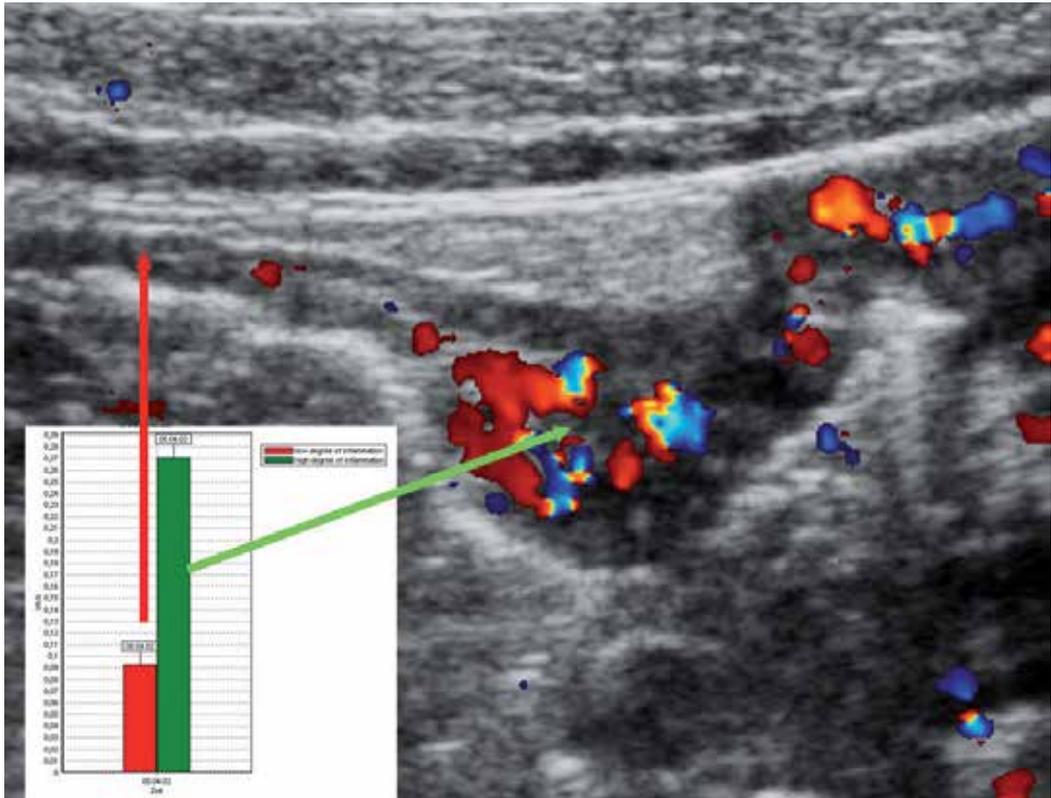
Same image as in fig. 8a in color Doppler mode. Inset showing the results of dynamic tissue perfusion measurement in both segments.
